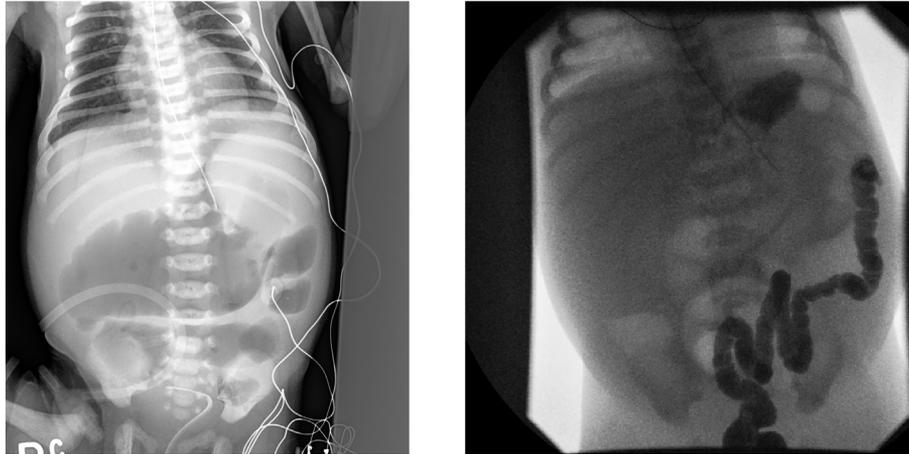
Intestinal atresia: plain radiograph and contrast enema showing microcolon.
